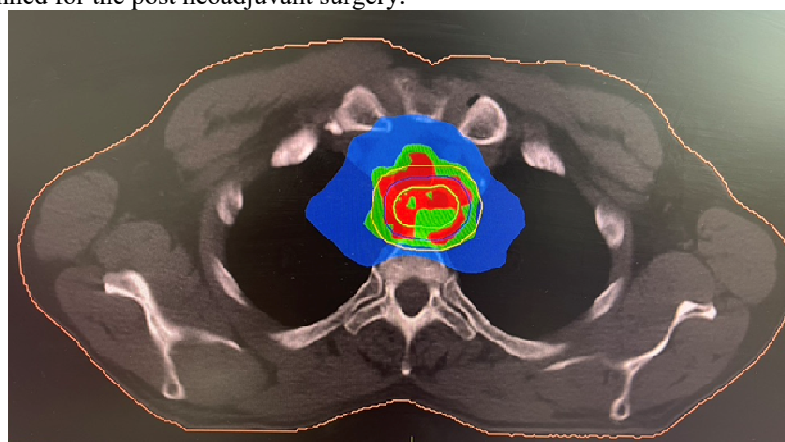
Locally advanced squamous cell carcinoma of upper thoracic esophageal cancer treated with IMRT. Axial CT image of the IMRT treatment planning showing the 100%, 95% and 50% of prescription dose distribution.
